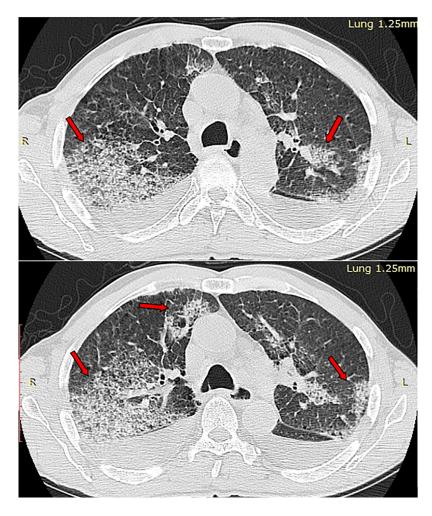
Thoracic CT scan showing a worsening of the pulmonary lesions.
